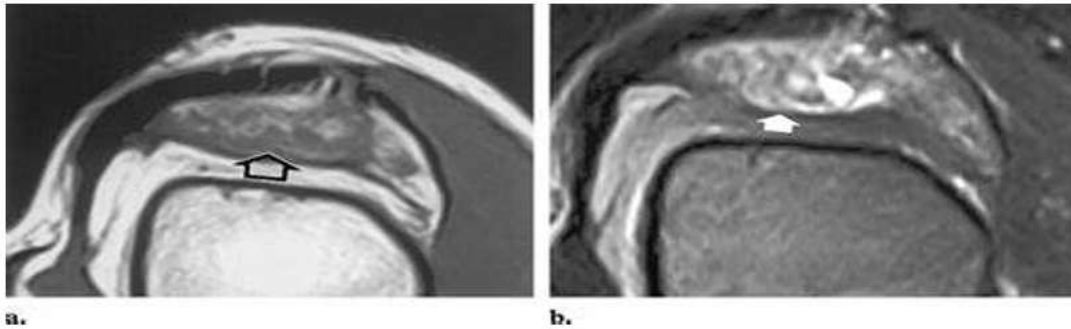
Synovial hemangioma of the knee. (a) Axial T1-weighted MR image shows an intermediate-signal-intensity lesion in the suprapatellar pouch (arrow) containing areas of high signal intensity. (b) On a corresponding axial fat-suppressed T2-weighted MR image, the lesion demonstrates the characteristic circular-linear pattern (arrow)[25].
